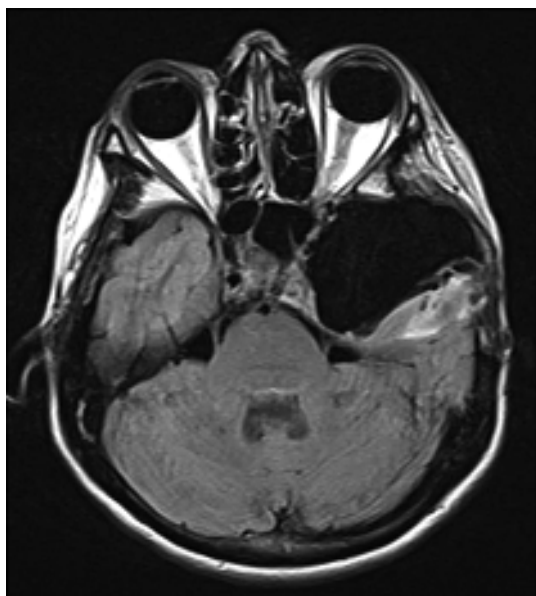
3 months post-op control MRI (after radiation therapy).
